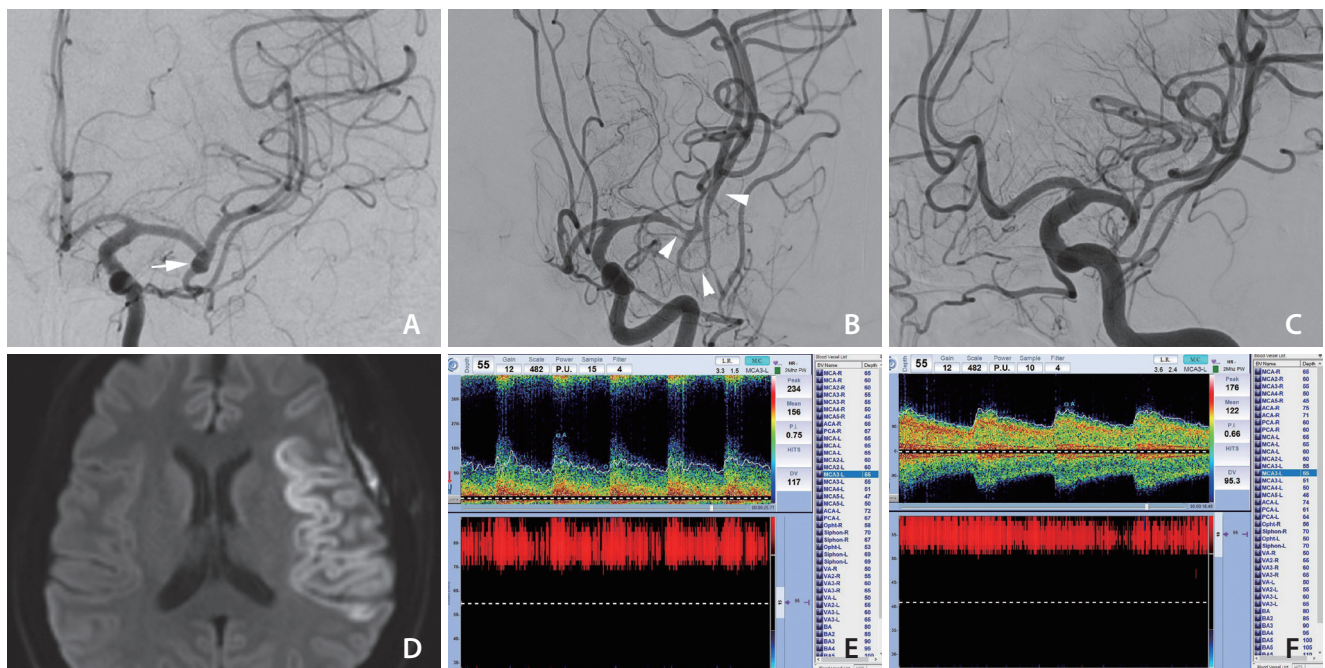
Digital subtraction angiography (DSA) findings and transcranial Doppler changes before and after treatment. (A) DSA image showing a normal vascular diameter and normal vascular appearance at the initial exam. Contrast stagnation was observed at the left middle cerebral artery (MCA) bifurcation, suggesting an unruptured saccular aneurysm (white arrow). (B) Severe luminal narrowing around the MCA bifurcation (white arrowheads) and overdilated M2–3 segments were observed on DSA at the first neurologic deterioration. (C) Marked resolution of vasospasm was shown after intraarterial nimodipine. (D) Diffusion restriction at the left MCA territory was confirmed at the transferred hospital. (E) The mean flow velocity was increased (156 cm/s, 55 mm) and the Lindegaard ratio was 5, which are indicative of moderate to severe vasospasm. (F) Improvement of vasospasm was shown by transcranial Doppler monitoring after 2 nimodipine injections.
